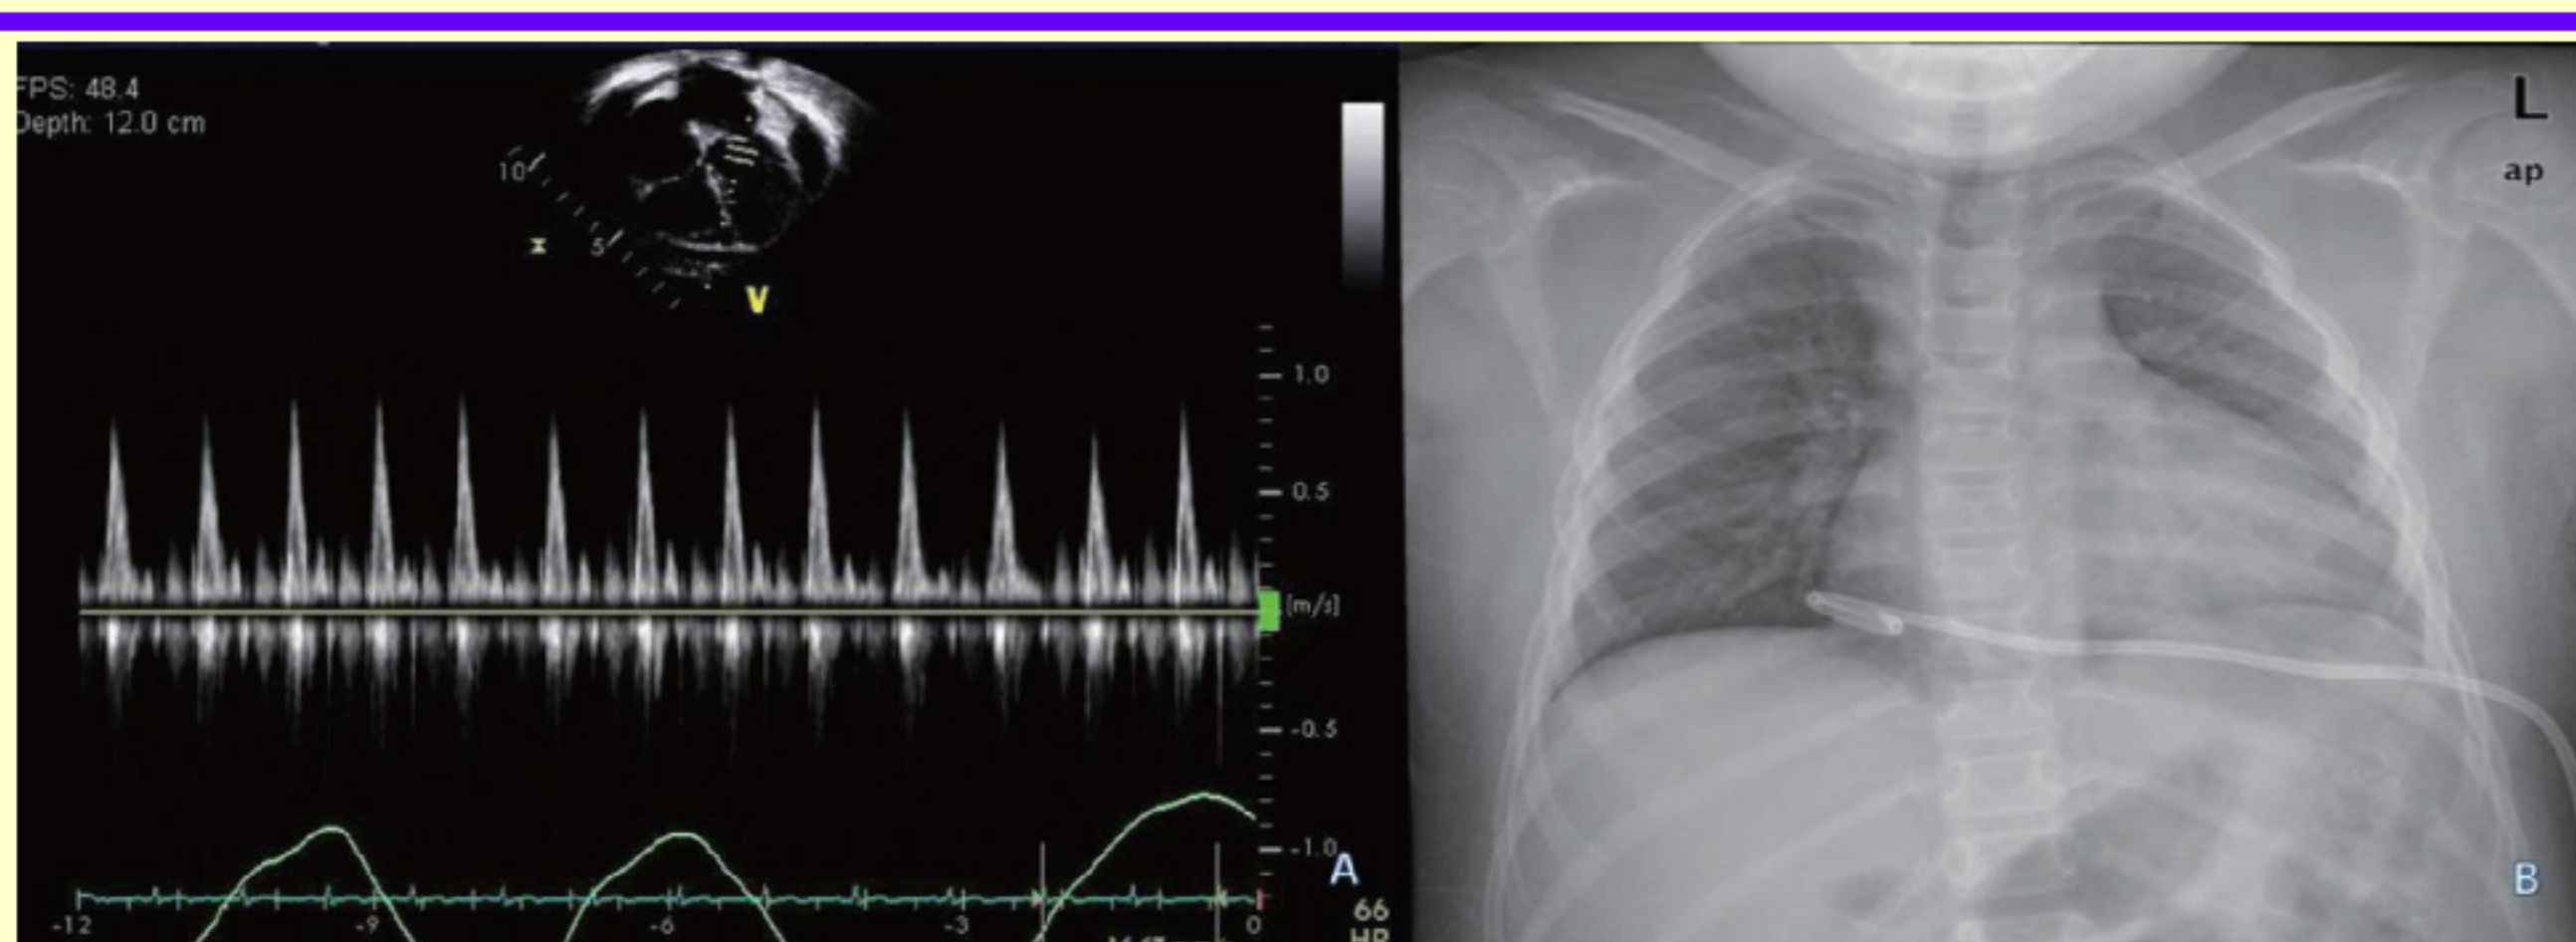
Echocardiography revealed massive pericardial effusion around the heart and fluctuating mitral inflow pattern recorded according to respiration (A), and closed pericardiostomy was performed with pericardial catheter (B).
